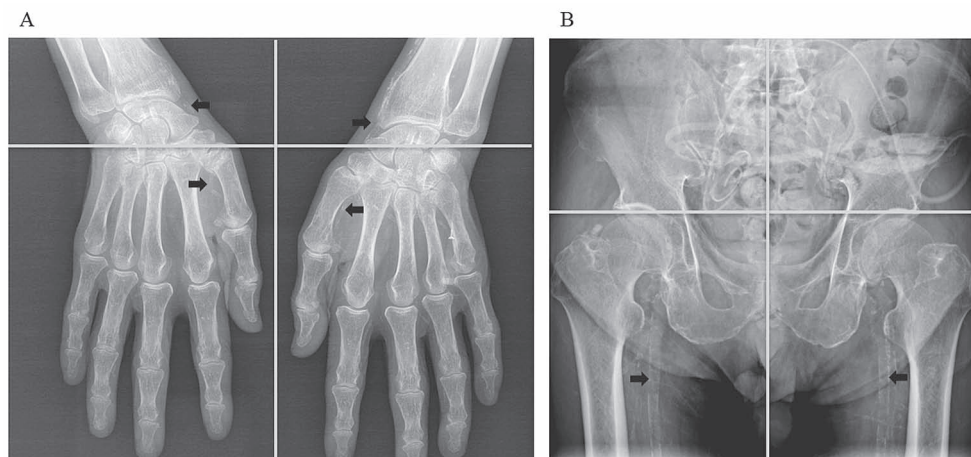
Vascular calcification on plain radiographs of hands and pelvis. Plain radiographs of hands (A) and pelvis (B) shows significant vascular calcification (VC) with VC score of the hands and pelvis ≥ 3 . Arrows indicate VC like angiopathy.
